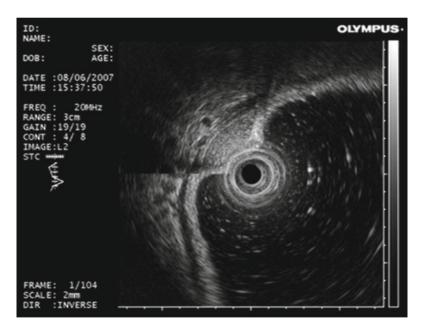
Endosonographic imaging with a high-frequency ultrasound miniprobe demonstrates an ovoid mass in the third echolayer (submucosa). The submucosal location and shape of the lesion is suggestive of a lipoma, but the echotexture is less hyperechoic. Endoscopic resection demonstrated a submucosal myxoid angioma.
